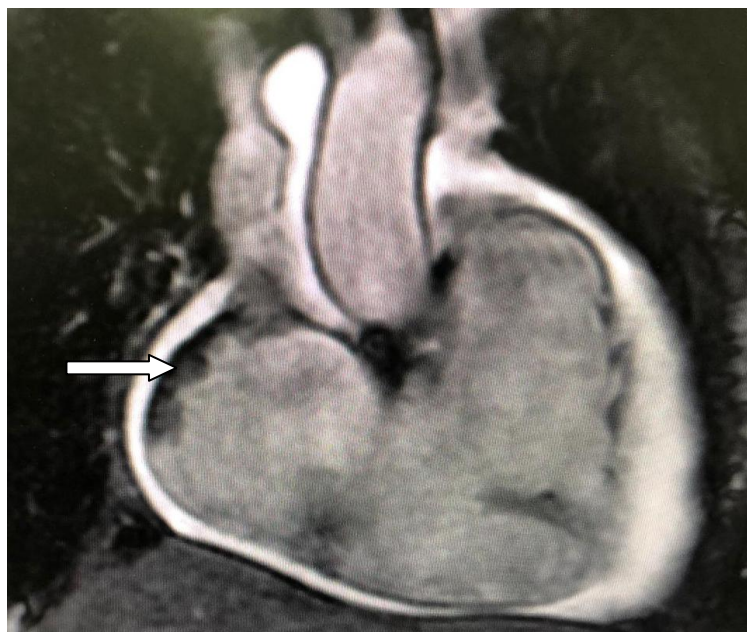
Cardiac MRI: cross section view: showing a dilated right ventricle with an altered systolic function (ejection fraction of 21%) without late enhancement signal to witness fibrose depot
